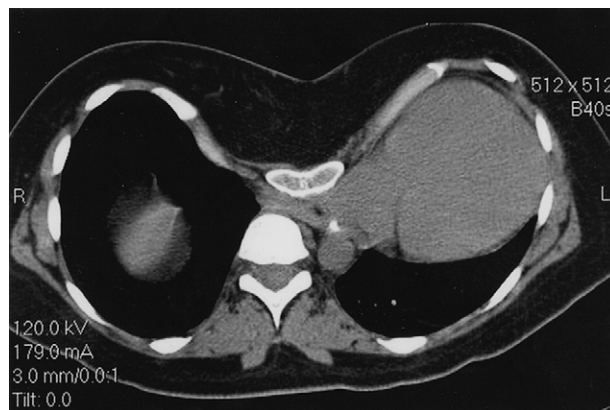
Computed tomographic scan from 51-year-old female with very severe pectus excavatum (severity index = 20.2). Note severe displacement of heart into left chest with compression of left lung.
